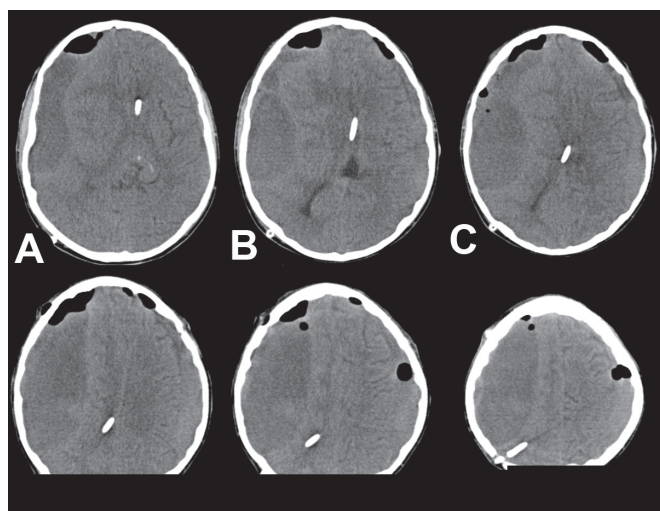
CT brain scan showing marked bilateral subdural haematoma (more to the right than the left) with midline shift to the left, and distorted and collapsed ventricles.
